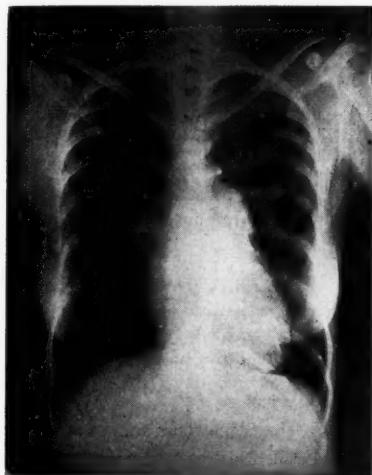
Roentgenogram demonstrating right ventricular enlargement and prominence of the shadow of the pulmonary trunk.
